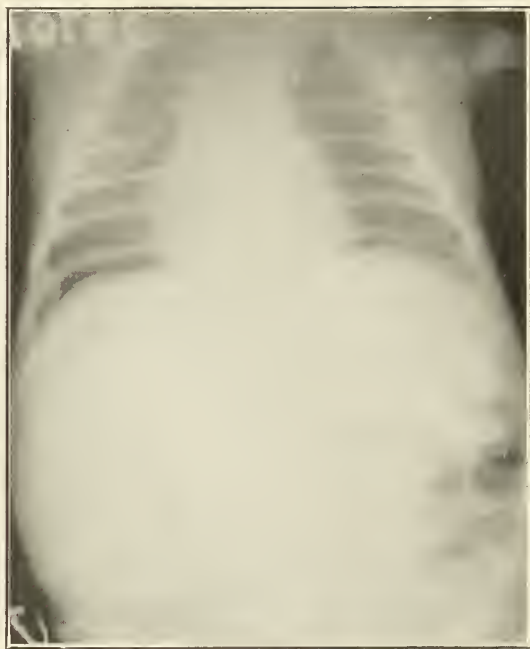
Same as figure 3. Symptoms relieved by roentgen ray treatment.
